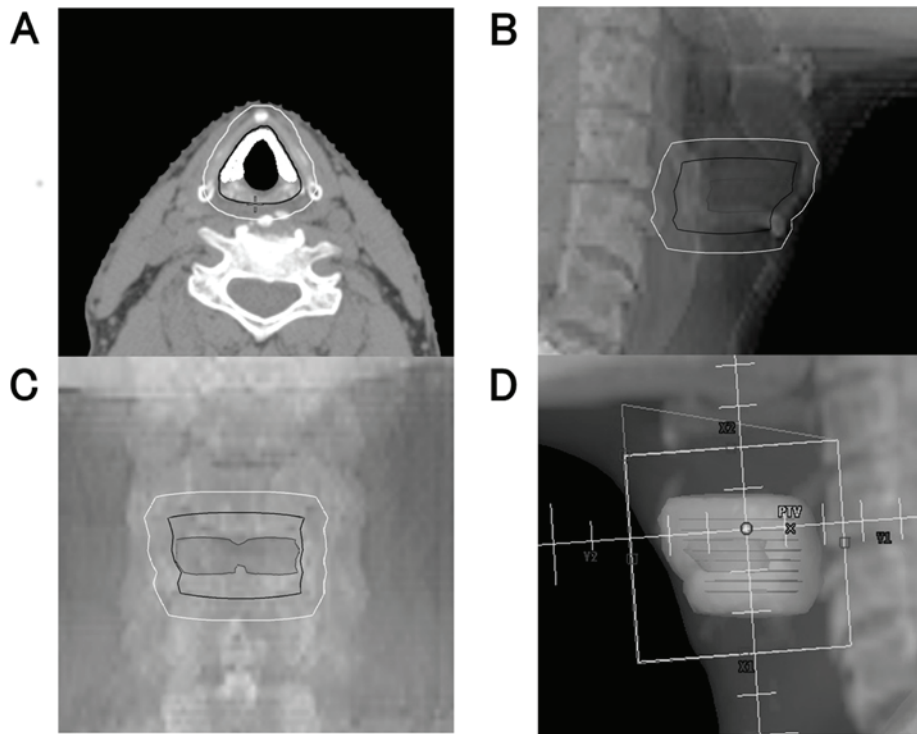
Typical contouring of the target volume and beam's eye view. (A) CT image for RT planning. The full white, black line and white line show the glottic larynx, CTV and PTV, respectively. (B and C) Sagittal and coronal tomography images for RT planning. (D) Beam's eye view of the typical field for RT planning. CT, computed tomography; RT, radiotherapy; CTV, clinical target volume; PTV, planning target volume.
